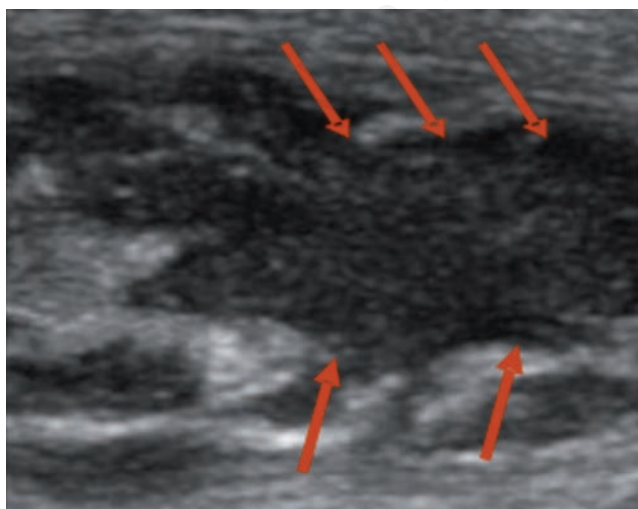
Bedside dynamic compression ultrasound showing a hypo-anechogenic area with fluctuating internal echoes, irregular margins of the left rectus abdominis muscle. The red arrows indicate the abscess.
